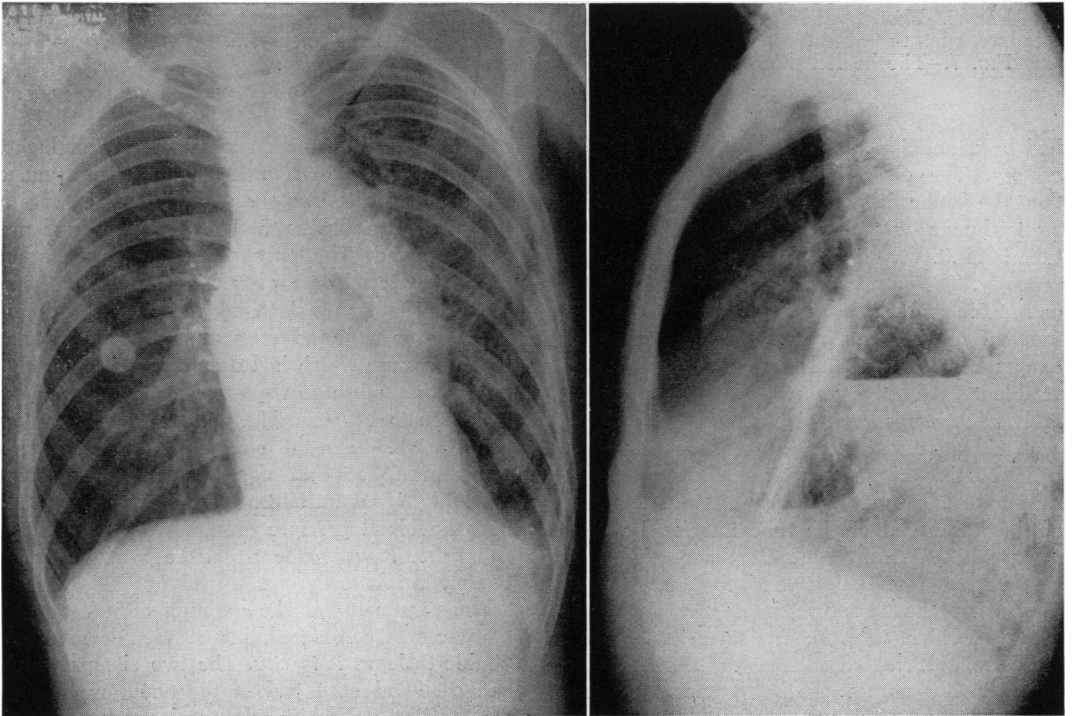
Roentgenograms taken 11 weeks after operation, showing a fluid level in the mediastinum. Note the fractures of the fifth and sixth ribs on the left, the result of coughing.
